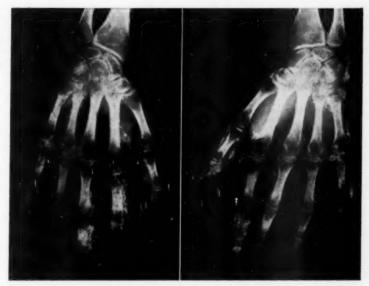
(Case 1.) Roentgenograms of the hands to show the amount of calcification.
